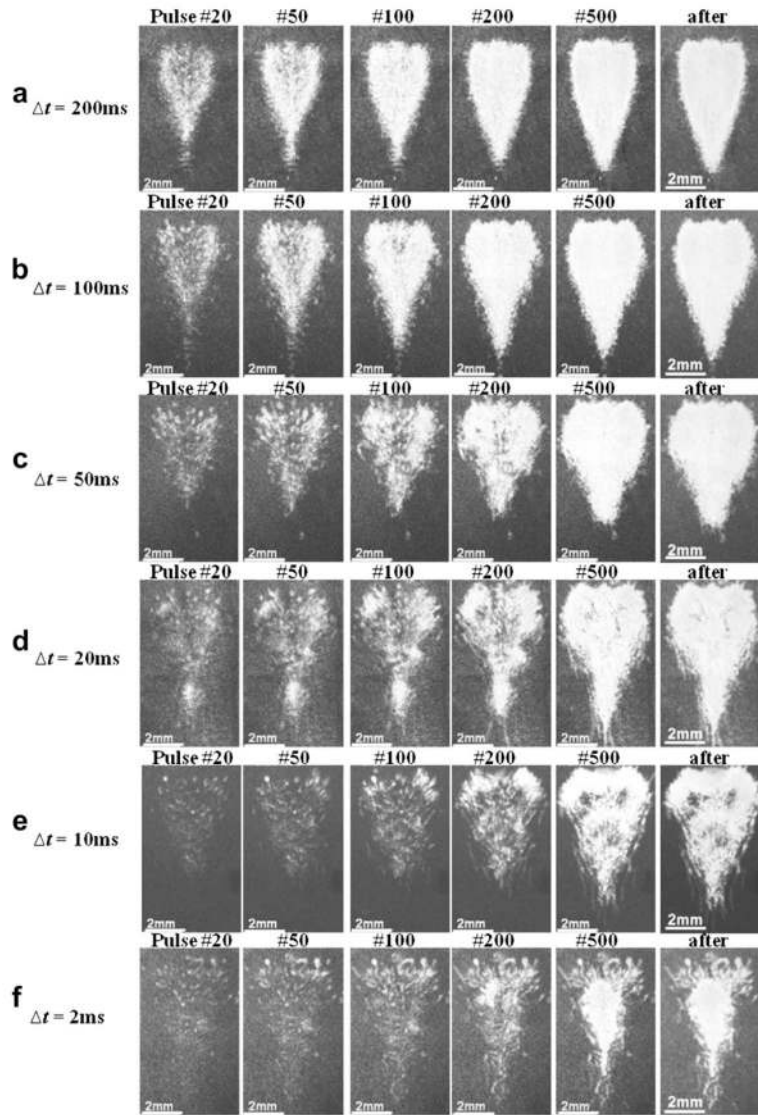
Overlay of the bubble images during the treatments when the time intervals between pulses decreased from (a) 200 to (f) 2 ms. The ultrasound propagation direction is from top to bottom of the image. When  $\Delta t$  was long, the focal volume was fully exposed to the cavitation bubbles within a small number of pulses (panel (a)). The number of pulses needed for the focal volume to be fully exposed to cavitation increased when  $\Delta t$  was decreased. When  $\Delta t$  was too short, full exposure could not be achieved within 500 pulses, and islands of untreated areas were present after the treatments (panels (e) and (f)).
